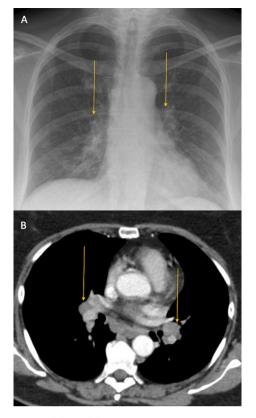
Images (A) and (B) show bilateral hilar lymphadenopathy on chest X-ray and computerised tomography (CT) of the chest, respectively (October 2020).
